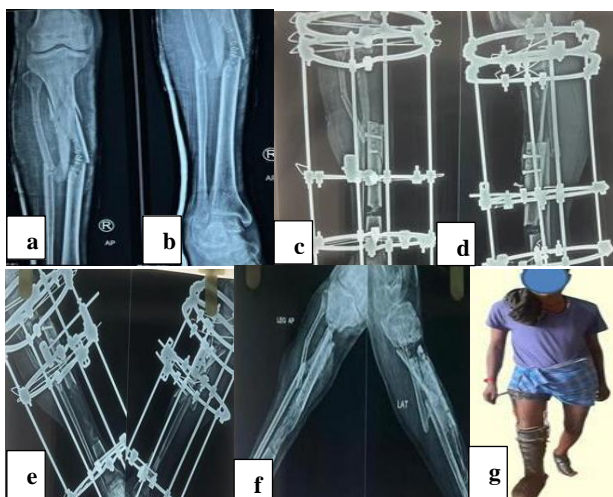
(a-g): Radiographs showing bifocal distraction-compression and after complication of bone transport and consolidation patient walking full weight bearing with hip knee ankle orthotics (HKFO).
